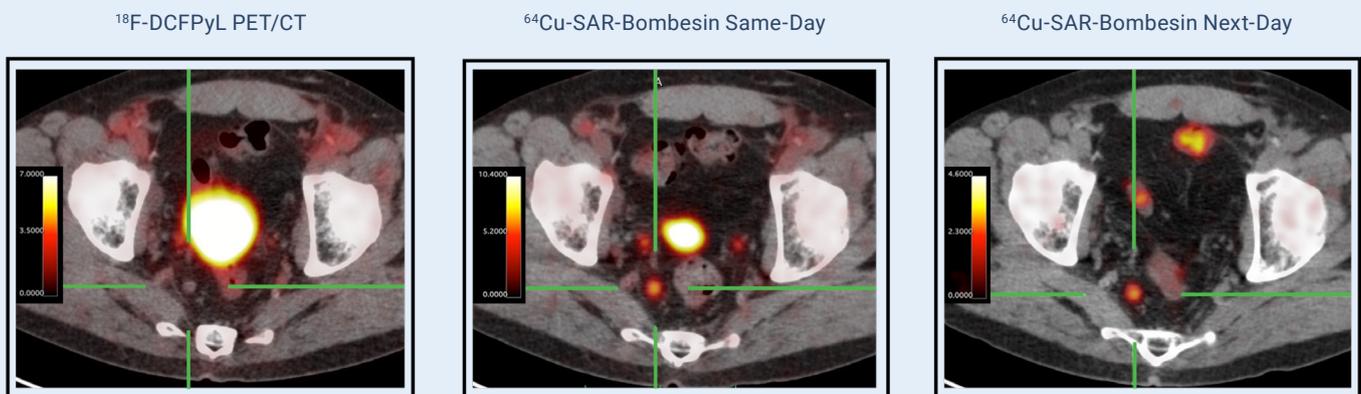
⁶⁴Cu-SAR-Bombesin detected a positive lymph node on scans performed on 2 different days (same-day and next-day scans). No uptake was observed using ¹⁸F-DCFPyL (Pylarify®) PET/CT. A subsequent biopsy, performed and assessed locally by the study site, confirmed prostate cancer.
